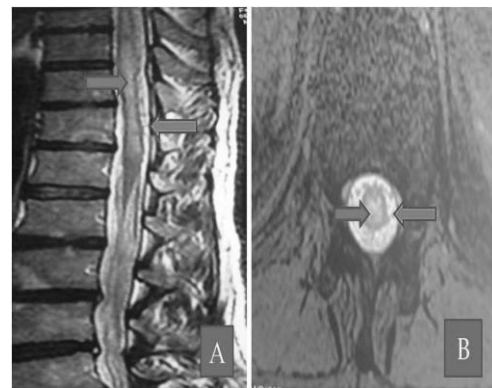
A: MRI sagittale T2 weithed showing flow void sign (yellow arrow) and intramedullar hyper intensity (red arrow).
